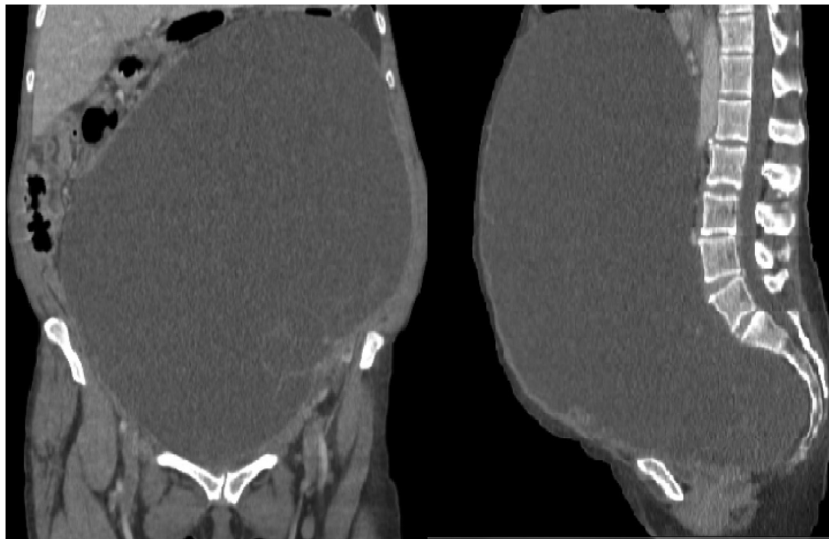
CT scan of abdomen and pelvis demonstrating mass.
